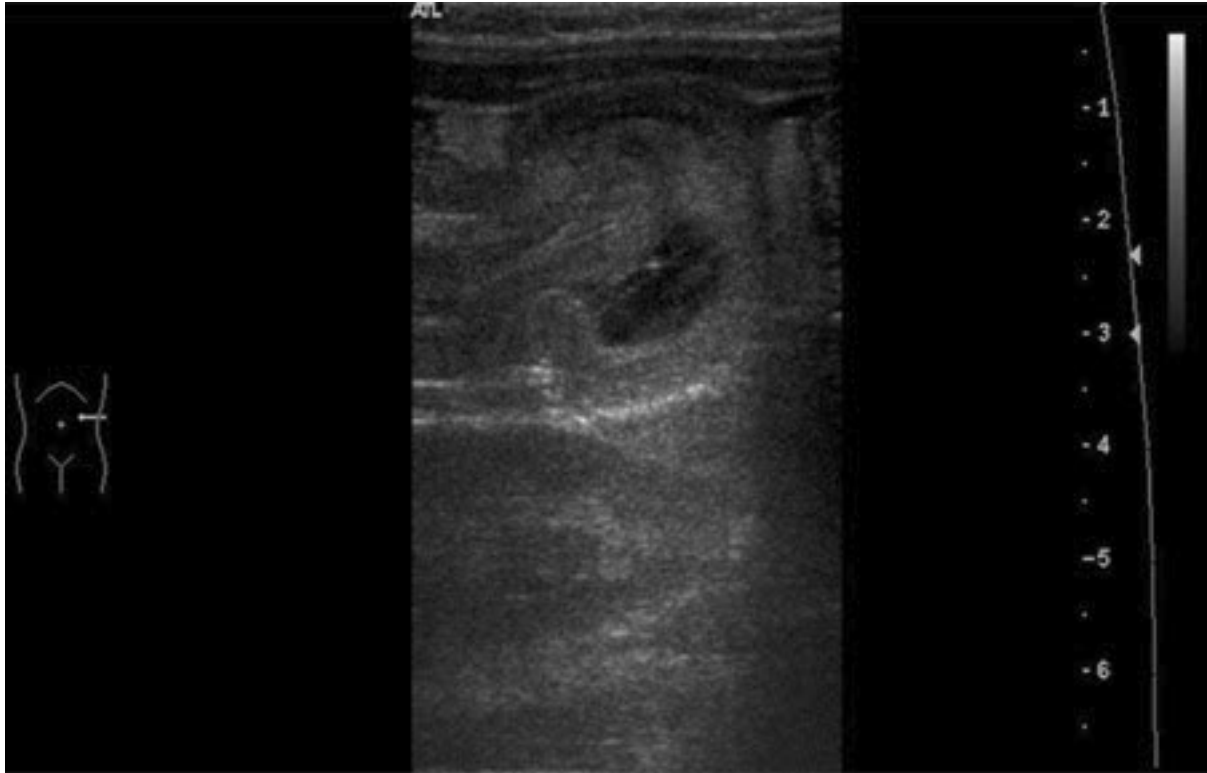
Intussusception: Ultrasound image showing invagination of a segment of bowel into the adjacent segment
